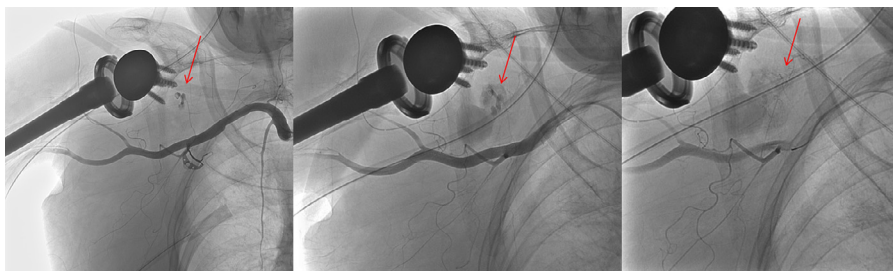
CT angiography of bleeding from the 1st branch of the thoracoacromial artery and failed embolization.
